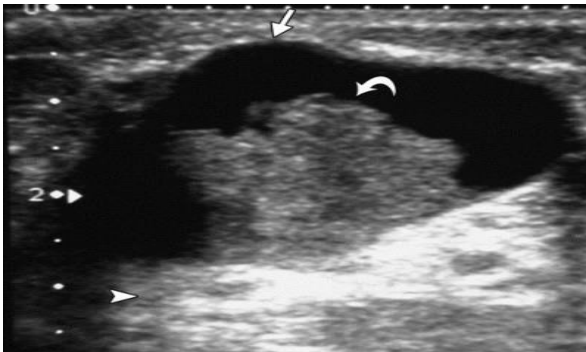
On ultrasound, they are hypoechoic, well-circumscribed lesion. Distal acoustic enhancement is seen.
